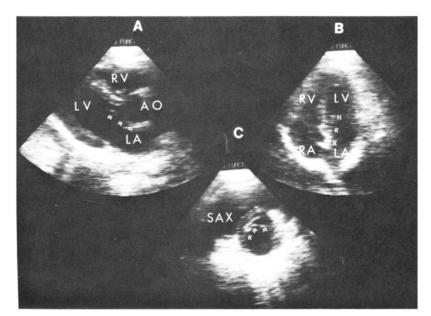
Normal maximal opening of the anterior mitral valve leaflet in early diastole. A, In the longaxis view, the opened leaflet is seen stretched across the aortic (AO) outflow tract (arrowheads). B, In the apical four chamber view, the leaflet lies flat against the septum (arrowheads). C, In the shortaxis view (SAX), the anterior leaflet is flush against the septum for almost half of its visible circumference (arrowheads). LA = left atrium; LV = left ventricle; RV = right ventricle.
